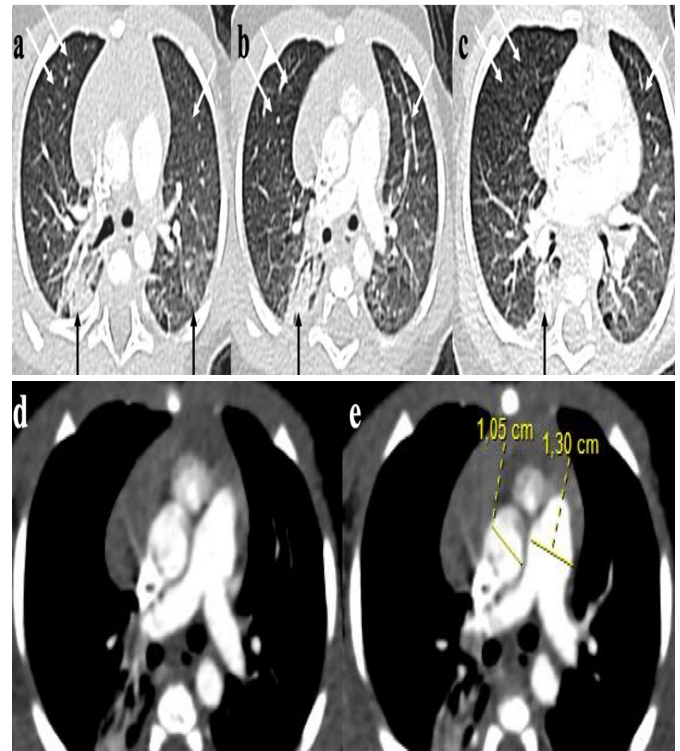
Axial contrast-enhanced chest CT images demonstrate hyperinflation areas in the anterior segments of both lungs (a, b, and c: white arrows). Additionally, there is evidence of subsegmental atelectasis, and pleuroparenchymal fibrotic changes observed in the posterior segments of bilateral lungs (a, b and c: black arrow). A prominent finding is the increased ratio of main pulmonary artery (pulmonary trunk) to ascending aorta (d, e), which correlates with elevated pulmonary artery pressure, suggestive of pulmonary hypertension.
